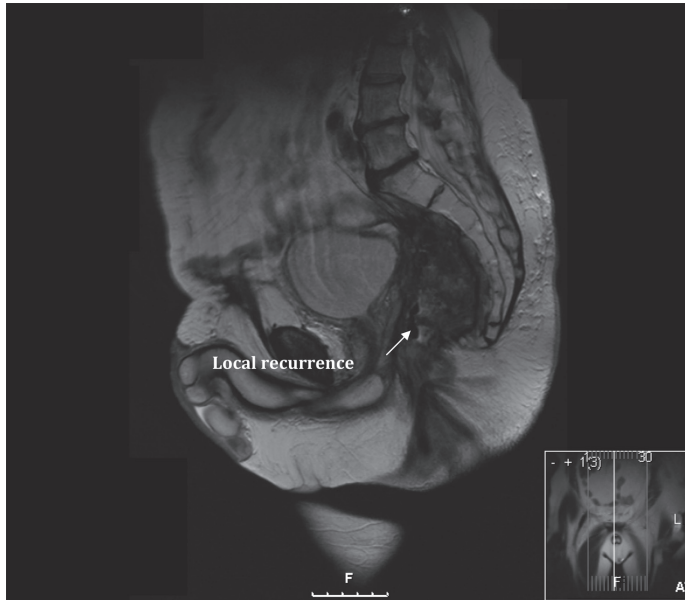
MRI: recurrent rectal cancer with close relation of the tumour with the sacrum
